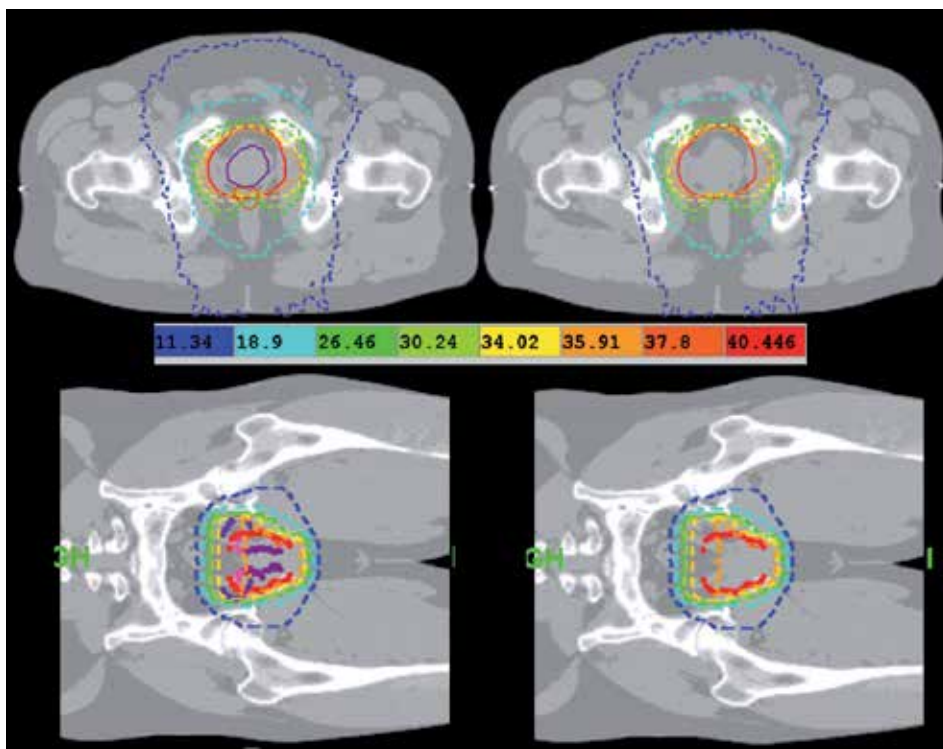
The reference CT slices of a prostate cancer patient are shown in the transverse and coronal planes for the Helical Tomotherapy dose distributions with (left) and without (right) patient setup correction. In each case, the dose values of the isodose lines are also presented.
